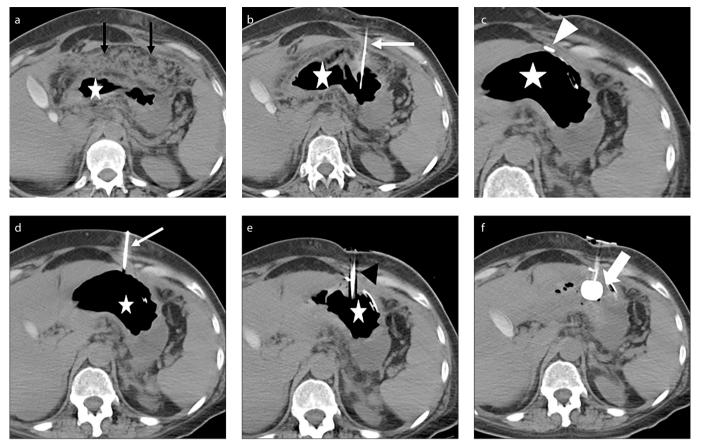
a–f. Multiple sequential axial unenhanced CT images: Panel (a) shows a case of peritoneal carcinomatosis (*black arrows*). In order to avoid placing a G-tube through the infiltrated omentum, CT guidance was chosen for G-tube placement. Panel (b) shows needle (*white arrow*) to place the T-fastener entering the anterior stomach wall, with its tip in the lumen of the stomach (*white star*). In panel (c), after successful deployment of the T-fastener (*white arrowhead*), the stomach (*white star*) is tacked to the anterior abdominal wall. Panel (d) shows 18 G access needle (*white arrow*) about to puncture the anterior wall of the air-filled stomach (*white star*). Panel (e) shows 22 G peel-away sheath (*black arrowhead*) in the stomach (*white star*), after serial dilatation over an Amplatz wire. Panel (f) shows a G-tube placed in the lumen of the stomach with the balloon inflated (*white block arrow*).
